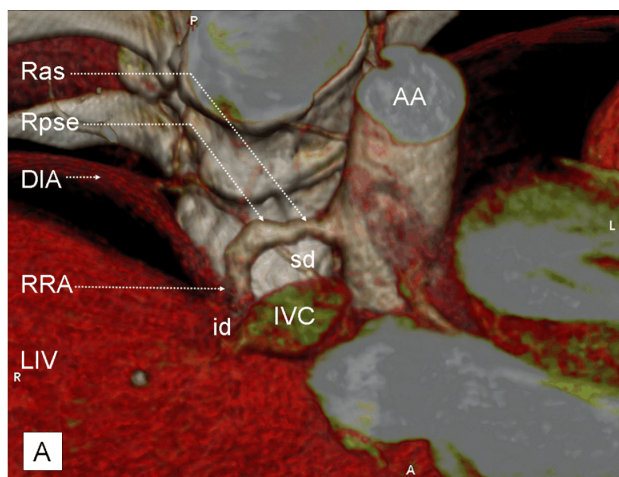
Coronal volume rendering images demonstrates the abdominal aorta with the origin of the inferior phrenic arteries (right and left). AA: Abdominal aorta; CT: Celiac trunk; LIPA: Left inferior phrenic artery; RIPA: Right inferior phrenic artery; LRA: Left renal artery; RRA: Right renal artery [id: Infradiaphragmatic part; sd: Supradiaphragmatic part]; SMA: Superior mesenteric artery.
